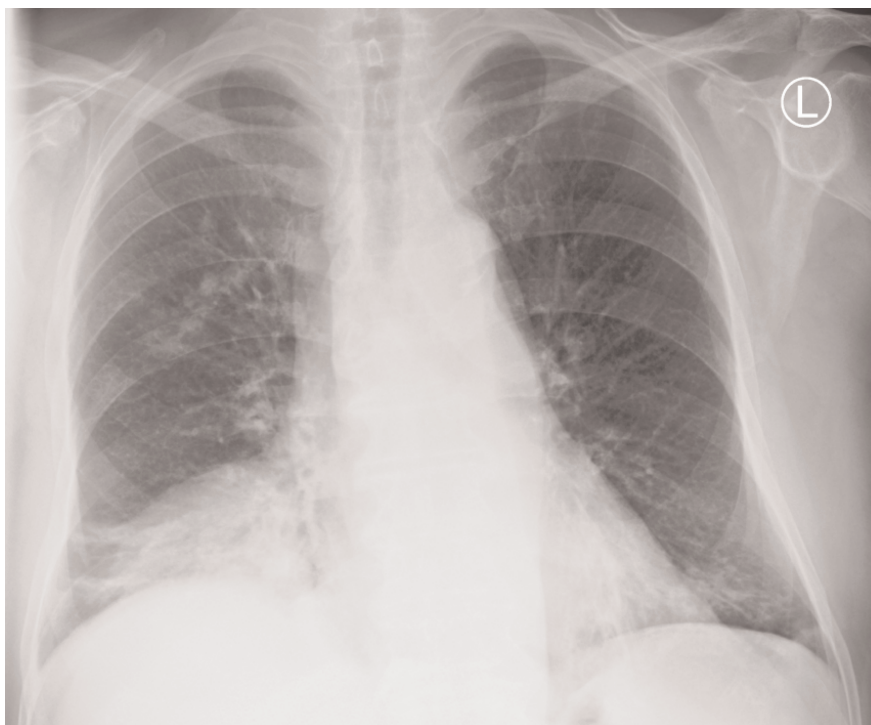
Preoperative antero-posterior chest X-ray image revealed multiple right-sided basal infiltrates which were consistent with asymptomatic pulmonary nocardiosis
